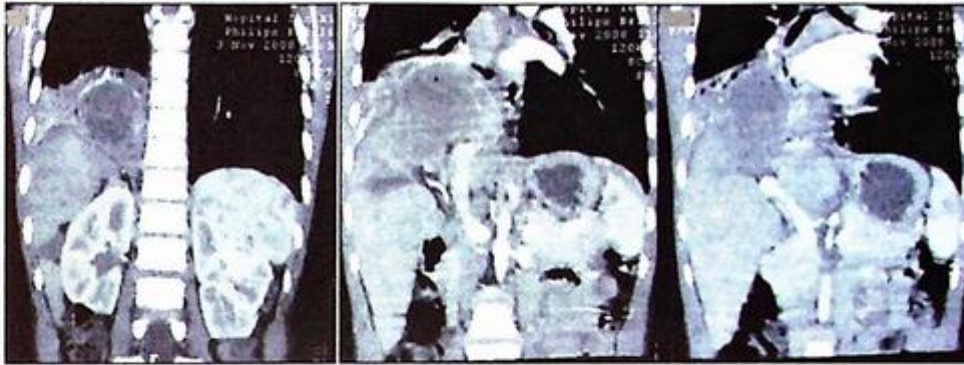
CT scan revealing a hydatid cyst of the hepatic dome complicated by intrathoracic rupture into the bronchial tree
